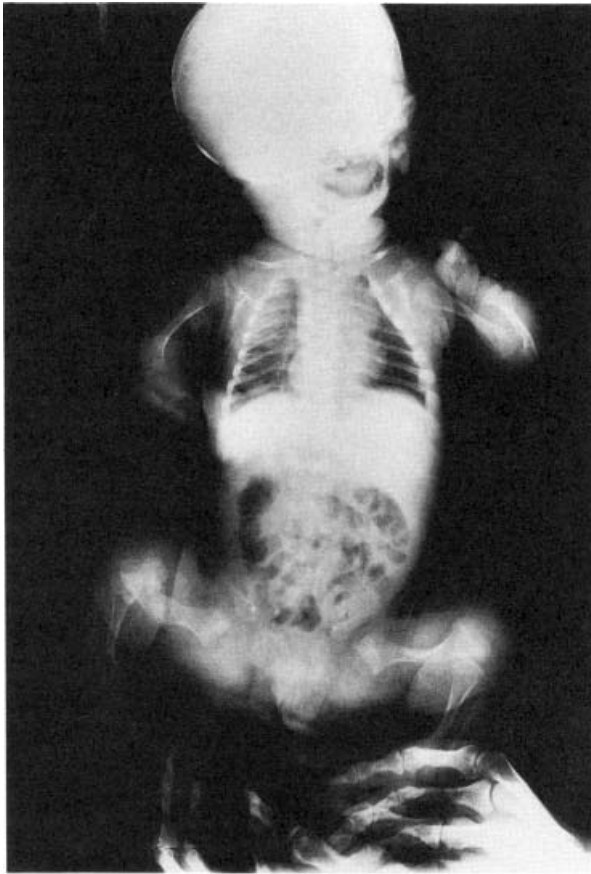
Radiograph taken shortly after birth of an infant with OI type III. Calvarial mineralization is decreased, the ribs have a near-normal size and configuration, and there is marked deformity of the long bones of the lower limbs. This infant is heterozygous for a mutation that results in the substitution of the glycine residue at position 526 of the $\alpha 1(I)$ chain by cysteine. (Reprinted from Starman et al. [65] by copyright permission of the American Society for Clinical Investigation.)
